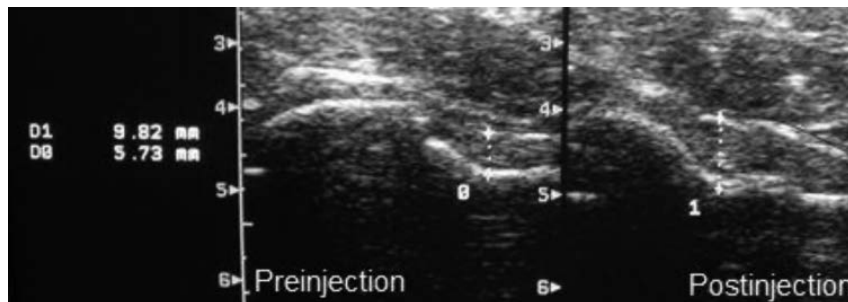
Reassessment by ultrasound immediately post-injection to examine the expansion of the joint capsule in order to ascertain the presence of the drug in the joint space D0: capsule distention pre-injection = 5.73 mm, D1 capsule distention post-injection = 9.82 mm.
